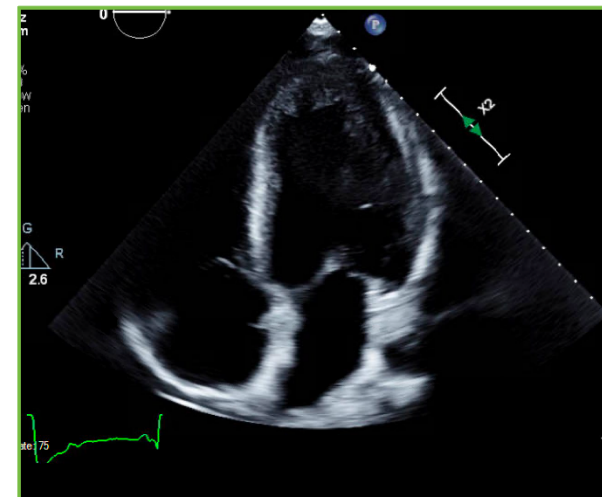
TTE without evidence of intracardiac thrombus; apical 4-chamber view
